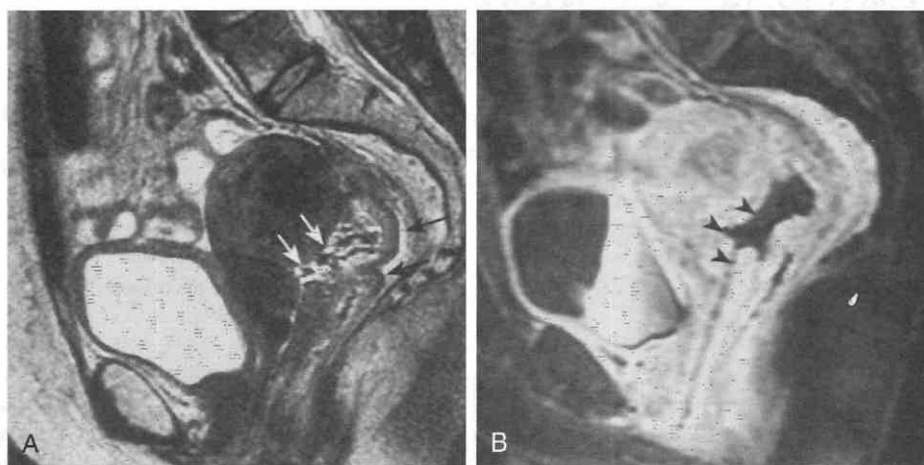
Rectovaginal fistula. Sagittal T2-weighted, fast spin-echo (*A*) and gadolinium-enhanced, fat-saturated (*B*) images in a patient after radiation for cervical carcinoma in whom fistula was not suspected at MRI. *A*, A high-signal-intensity tract (*white arrows*) extends from the rectum into the vaginal fornix. Although the posterior rectal wall is well delineated (*black arrows*), a defect in the anterior rectal wall leads into the fistula. *B*, The tract is nonenhancing (*arrowheads*). Incidentally noted are radiation changes in the spine and presacral space.
